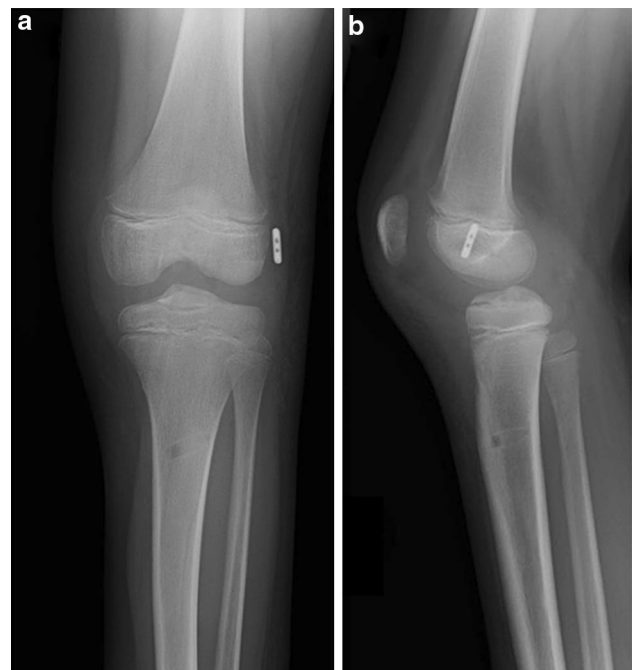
Post-operative imaging: a anteroposterior and b lateral post-operative radiographs confirm implant positioning and fixation. The cortical fixation device is fully seated in direct contact with the thick uncalcified periosteum
